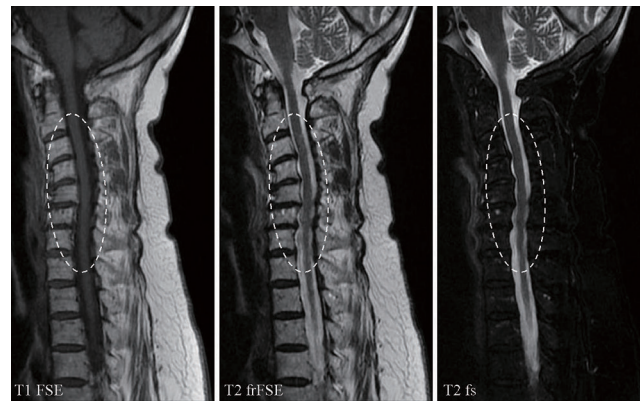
Magnetic resonance imaging, including a T1 fast spin echo sequence (TR/TE/excitation: 667/11.2/1), T2 fat relaxation fast spin echo sequence (TR/TE/excitation: 3100/100.7/1), and T2 fat saturation sequence (TR/TE/excitation: 2933/116.4/1).
